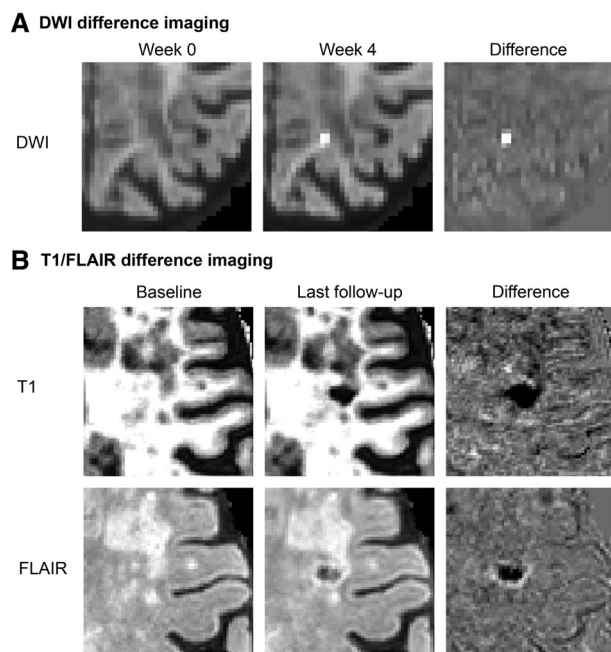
Incident lesion detection using difference imaging. (A) Diffusion-weighted imaging (DWI) difference images were created by subtracting registered DWI trace images (shown here $b = 3,000$) from consecutive magnetic resonance imaging (MRI) visits to detect incident DWI+ lesions. (B) Incident lacunes were detected on T1 and fluid-attenuated inversion recovery (FLAIR) difference images created by subtracting registered baseline T1 and FLAIR scans from the last available follow-up scan.
